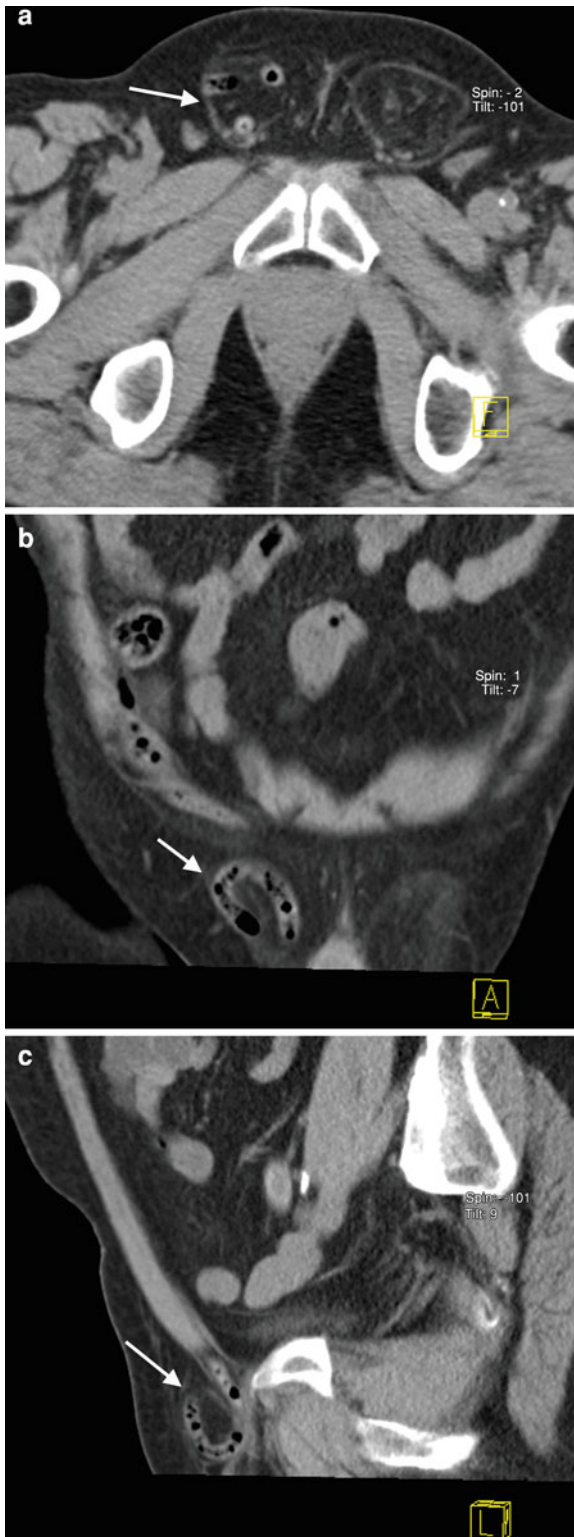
a, b, c Normal appendix located in a right inguinal hernia (arrow) seen on axial (a), coronal (b), and sagittal CT images (c)
